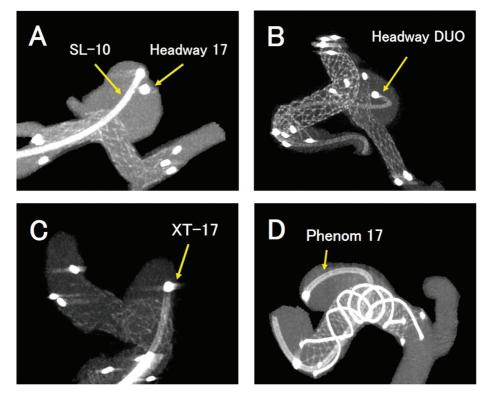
Differences in the visibility of various microcatheter tips by cone-beam CT. (A) Excelsior SL-10 (Stryker) and Headway 17 (Terumo). (B) Headway DUO (Terumo). (C) XT-17 (Stryker). (D) Phenom 17 (Medtronic).
